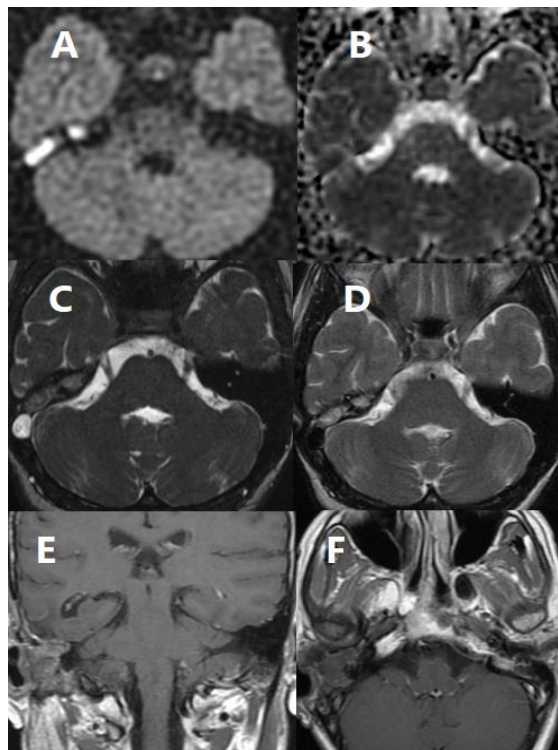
Selected MRI images that were verified during surgery and showed a signal of postoperative recurrent/residual cholesteatoma: DWI (A). ADC (B). Axial T2 high-resolution (C). Axial T2 SE WI (D). Post-contrast coronal T1 (E). Post-contrast axial delayed T1WI (F). An opacified right mastoid antrum with a soft tissue signal lesion without intracranial extension displays a confined diffusion restriction pattern (High DWI signal and low ADC map signal), high signal in T2, high-resolution T2 WIs, and a slight non-uniform post-contrast enhancement.
